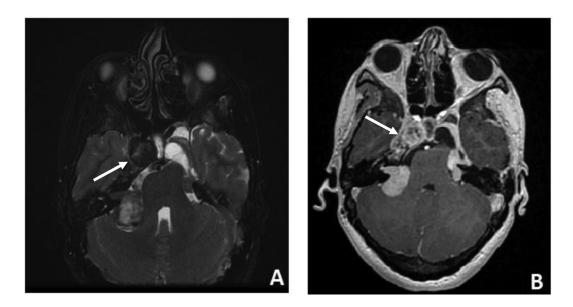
Axial T2 (A) and T1-weighted contrast-enhanced (B) MR images showing masses occupying the Meckel's cave (white arrows).
